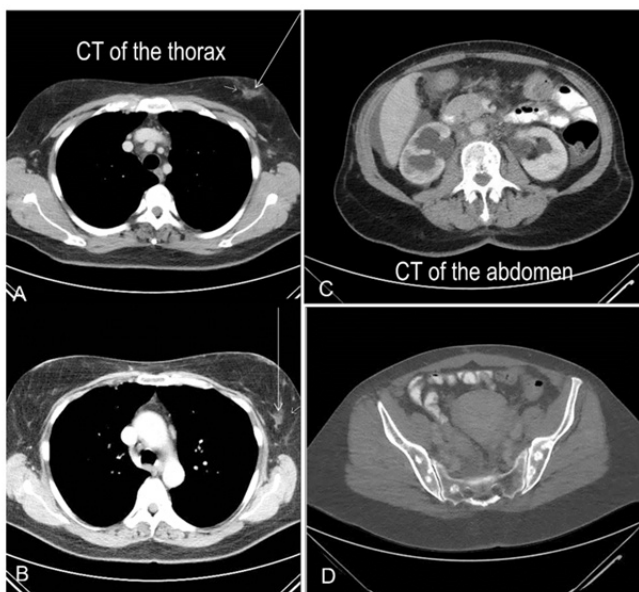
Thorax CT demonstrates a breast tumour (arrows). CT of the abdomen revealed diffuse abdominal carcinosis, which also infiltrated the retroperitoneal adipose tissue and compressed the inferior vena cava and ureters, causing bilateral hydronephrosis in addition to sclerotic and lytic metastases of the pelvic bones.
